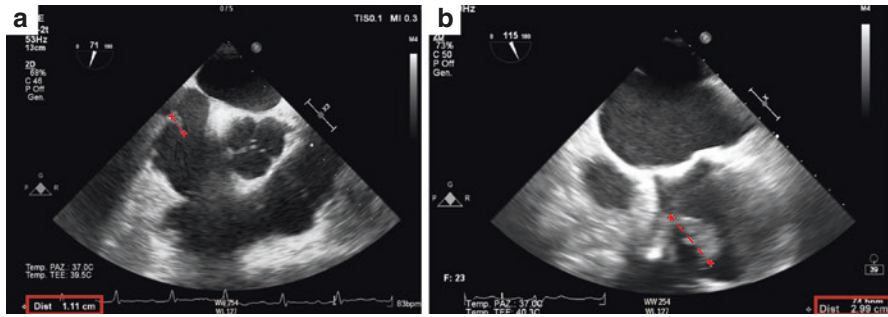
Measurement of endocarditic vegetations. Echocardiography represents a useful tool for the measurement of endocarditic vegetations. Pictures a and b, obtained from transesophageal echocardiogram of two different patients with CIED infection, show vegetations of different size (highlighted in red)
